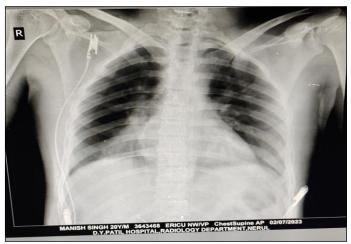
Chest radiography showing bilateral infiltrates
